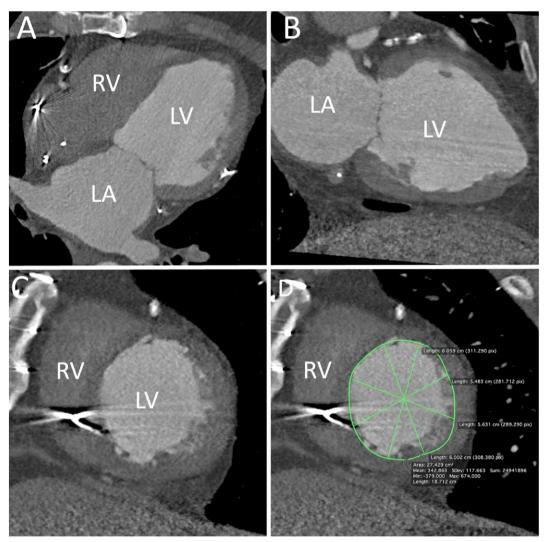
Multidetector computed tomography pre-parachute device implantation. (A–D) Evaluation of the left ventricle at end systole to determine suitability and sizing for a Parachute device implant. (A) The 4-chamber view, (B) the 2-chamber view with a left ventricular apical aneurysm, (C) the short axis view at the base of the papillary muscles and (D) the measurements made for sizing of a Parachute device. LA denotes left atrium, LV—left ventricle and RV right ventricle.
